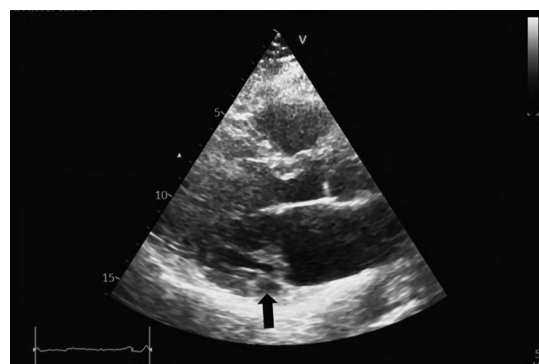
Parasternal long-axis view of the left ventricle. Diastole. The elongated and thickened mitral valve leaflets (predominantly posterior) are visible. The black arrow indicates the disjunction area below the posterior mitral valve leaflet.
